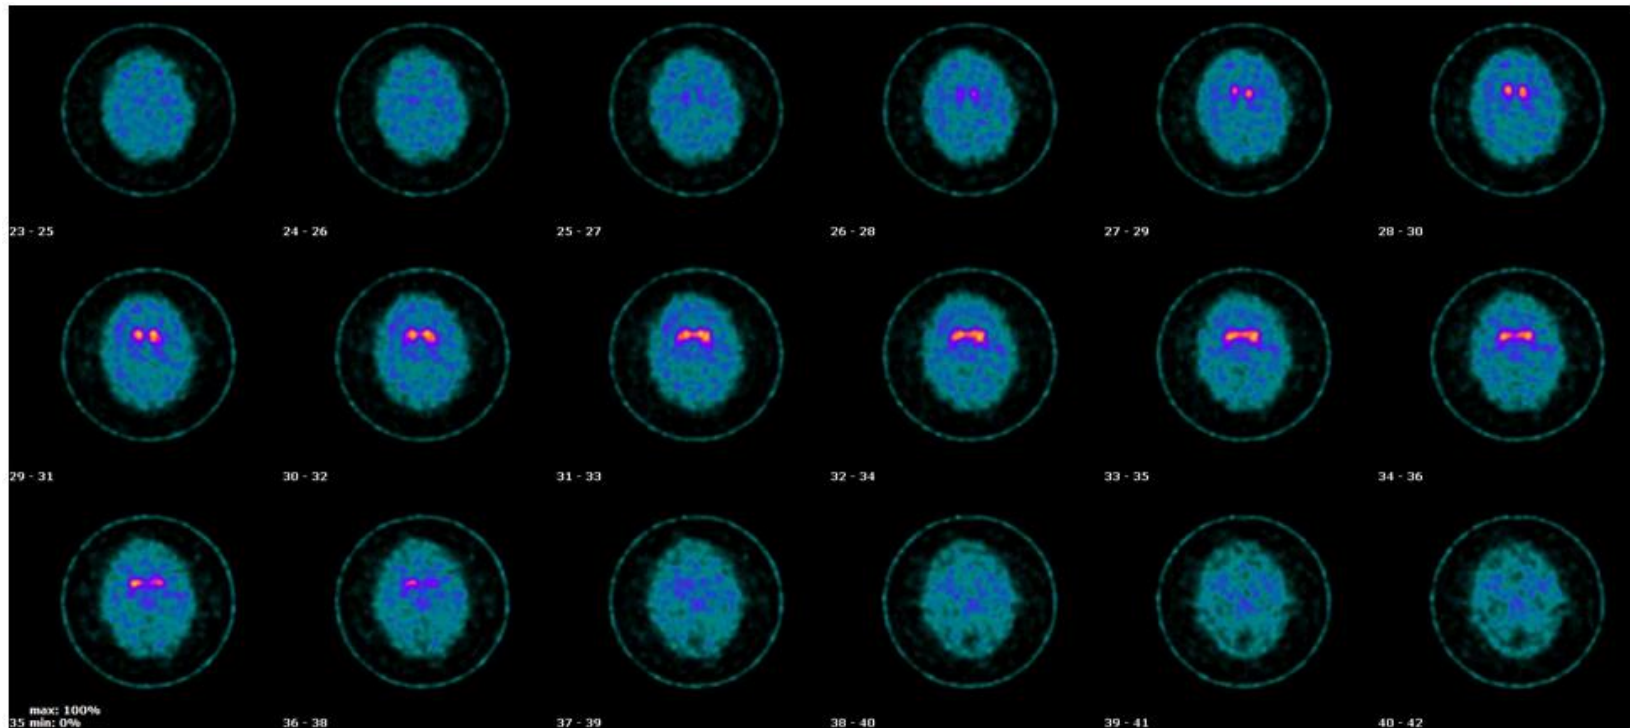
Example of routine DaTscan (^{123}I -Ioflupane SPECT), axial slices at the level of basal ganglia, slices 21 to 41, showing bilateral hypofixation of both putamen in a Parkinson's disease patient. Images are displayed in radiological convention. The pictures have been acquired in the nuclear medicine department of our hospital (University Hospital of Liège, Belgium).
